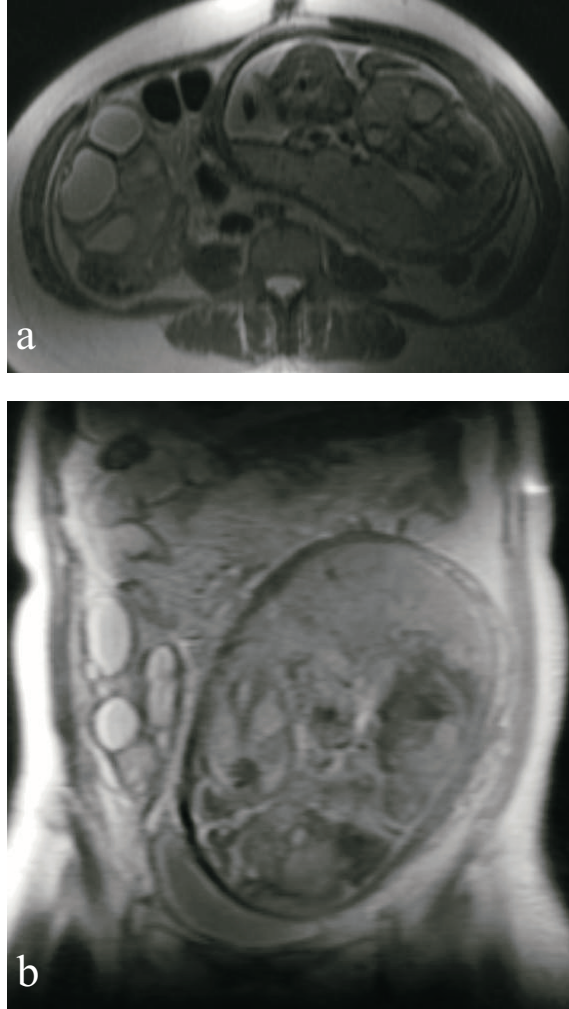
Right ovarian torsion and hemorrhage in a 23 year-old patient at 23 weeks of gestation. (a) axial T2-weighted SSFSE (TR/TE: infinite/80) (b) coronal T2-weighted SSFSE (TR/TE: infinite/80) images show enlarged right ovary 4 × 5 × 7 cm in size, containing multiple follicles. Lesion demonstrated curvilinear hyperintense areas on T1-weighted images and this was interpreted as a sign of introvarian hemorrhage (not shown). Surgery confirmed the diagnosis of right ovarian torsion and introvarian hemorrhage.
